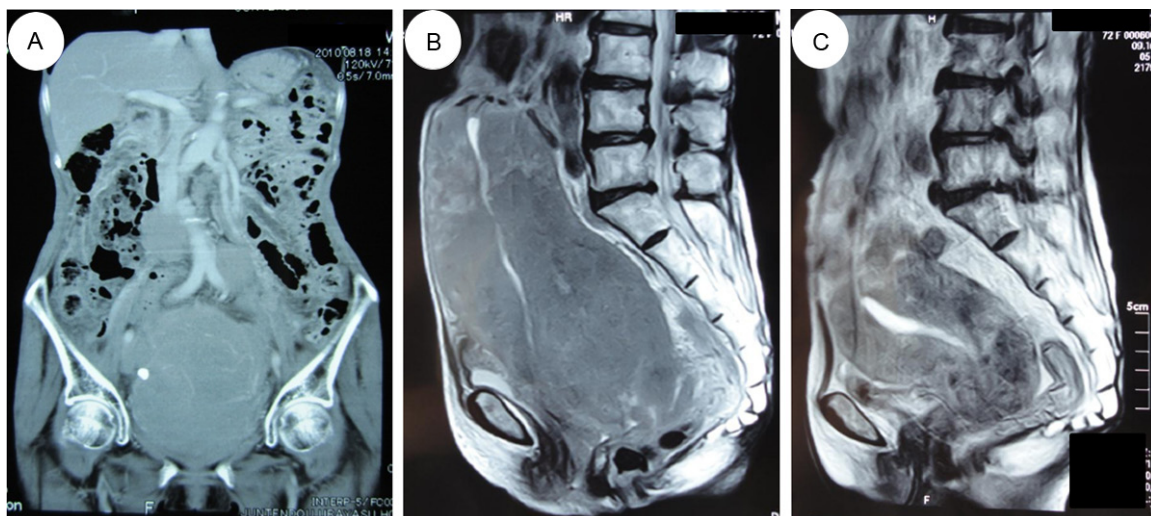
Pelvic computed tomography (CT) and Pelvic magnetic resonance imaging (MRI). A: The CT image before treatment showed intrapelvic lymph node enlargement. B: The MRI scan before treatment showed an enhanced uterine tumor with indistinct boundaries that measured 20 cm in diameter. C: MRI scan showing marked regression of the tumor after TC therapy (paclitaxel and carboplatin).
